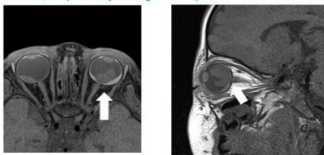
The axial (left) and sagittal (right) MRI T1-weighted images of a 2-month-old boy having retinoblastoma in both eyes. In left eye, there is T1-weighted hypointense retinoblastoma, with adjacent V-shaped T1-weighted hypointense subretinal fluid converging to the optic disc (white arrow), which is signature for retinal detachment.
